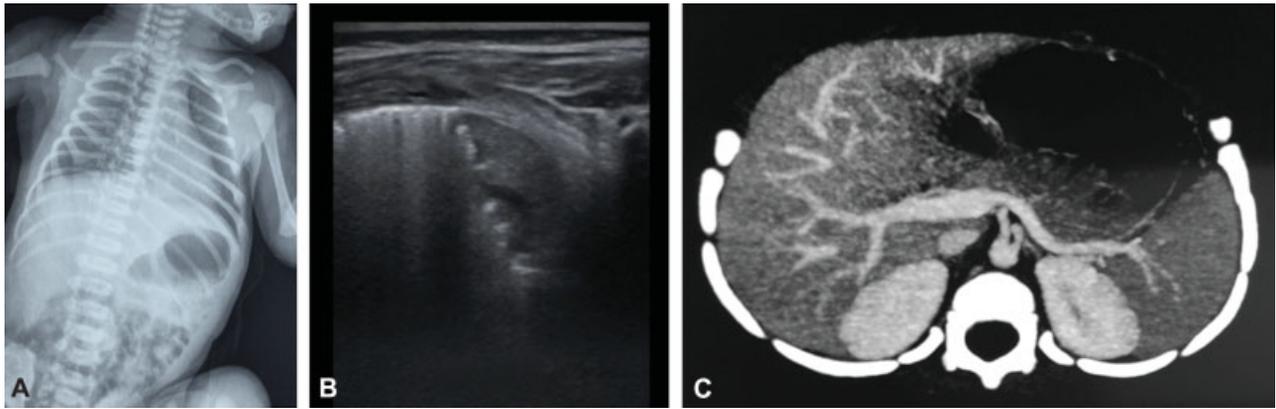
(A) CXR: left-sided diaphragmatic elevation. (B) LUS: pulmonary consolidation of the left lower lobe. (C) CT scan: pulmonary condensation of the posterior left lower lobe, fed by a systemic vessel branching from the thoracic aorta. The venous drainage is provided by the pulmonary system, suggesting the diagnosis of intralobar PS. CT, computed tomography; CXR, chest X-ray; LUS, lung ultrasound; PS, pulmonary sequestration.
